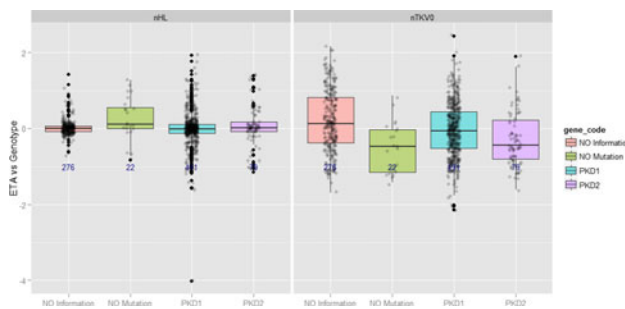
Random effects versus mutation (MRI model shown)
